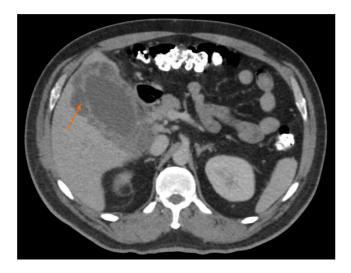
Abdominal computed tomography demonstrating discontinuity of the gallbladder wall consistent with perforation (orange arrow), as well as a soft tissue density in the area of the porta hepatis.
